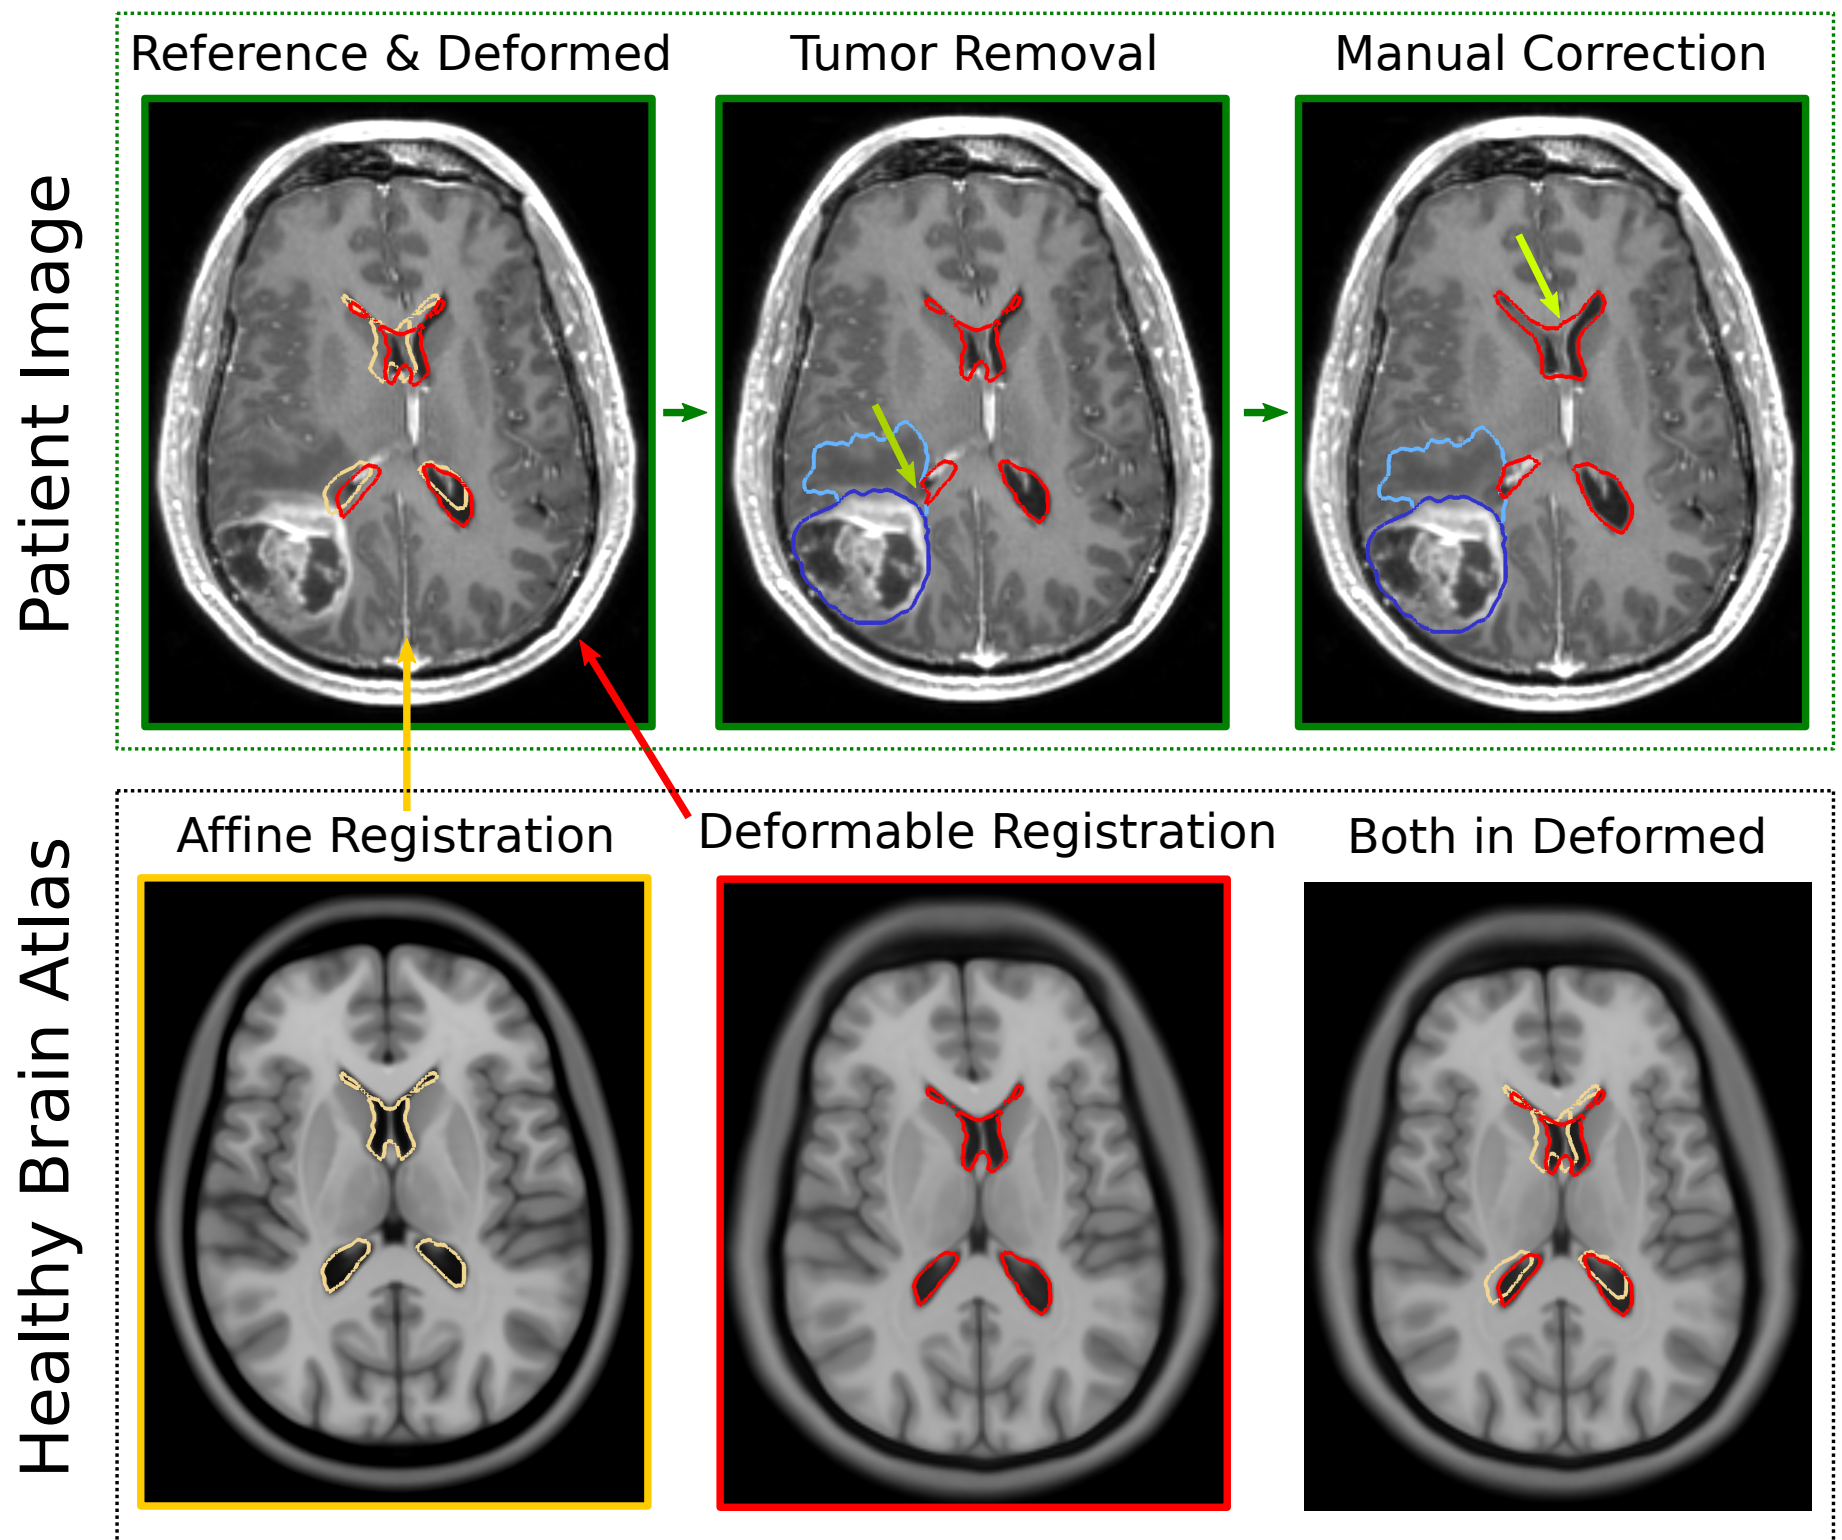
The patient’s “healthy” anatomy is approximated by affine registration of a brain atlas to the patient’s brain MRI. Deformed ventricles are segmented by deformable registration and subsequent manual correction. LVd is computed from the center-of-mass positions of reference and deformed ventricles.
